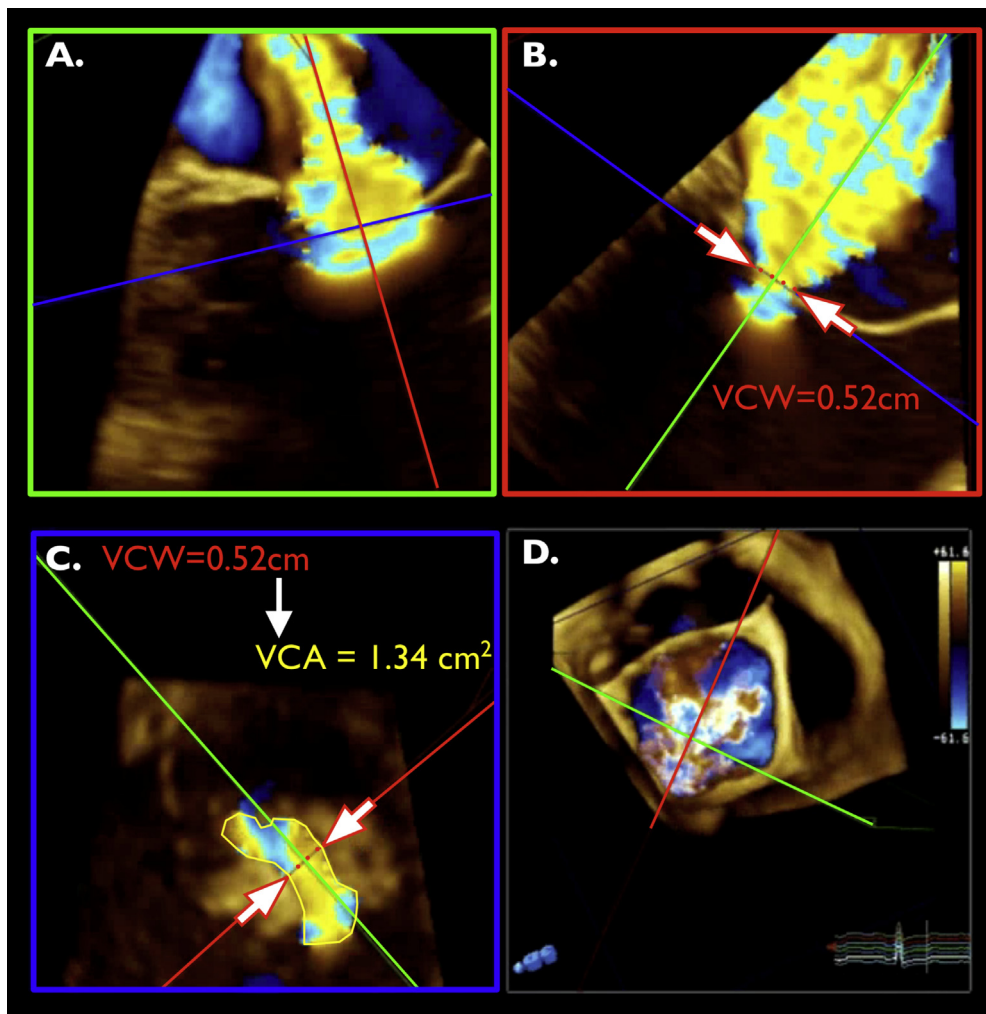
3D TEE multiplanar reconstruction planes in orthogonal orientation to the mitral regurgitant jet with color flow Doppler in a patient with severe functional MR. (A) The 3D volume has been cropped along a plane aligned with the width of the jet and is represented by the *green line* in the other views (B) The 3D volume has been sliced along a plane similar to a rotated 2D LAX view represented by the *red line* in the other views. (C) The 3D volume has been sliced along a plane aligned with the jet VC. The VC area (VCA) can be measured by tracing the jet area in this plane. Note that the VC width (VCW) of 0.52 cm (*white arrows*) would be consistent with moderate MR and significantly underrepresents the severity of the MR. As a surrogate for effective regurgitant orifice area, this patient's VCA (1.34 cm²) would classify the degree of MR significantly above the cutoff for severe MR. (D) A 3D view of the MV and the MR jet. The corresponding planes are represented by the *green and red lines*.
